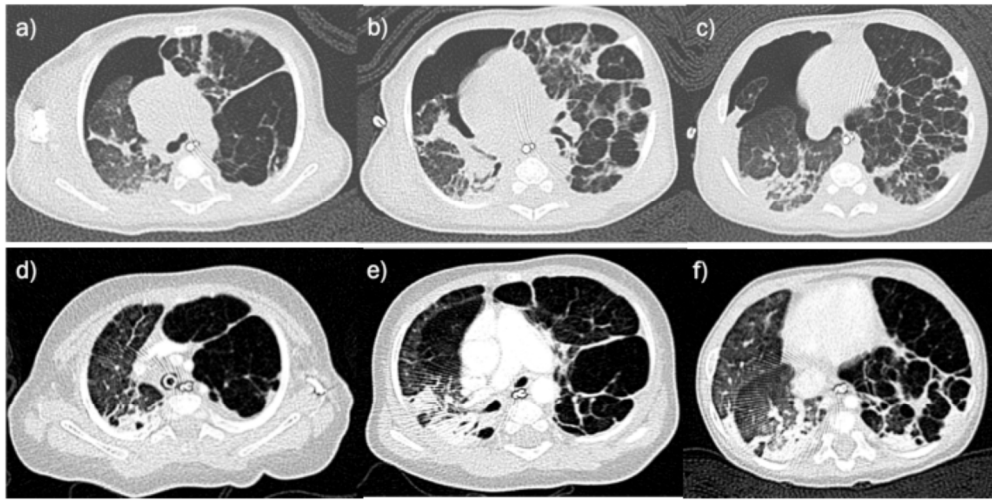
Case 1: Serial axial chest CT images (with lung windows) are displayed demonstrating lung changes with age. The top row (a to c) highlights imaging appearances within the upper, middle and lower zones respectively at 3 months of age. There is a moderate sized right pneumothorax with underlying ground glass change in the lung parenchyma. The left lung is hyperinflated with interlobular septal thickening and areas of air trapping. The bottom row (d to f) demonstrates lung appearances at 5 months of age reflecting on-going left lung hyperinflation and septal thickening. The pneumothorax is no longer present.
